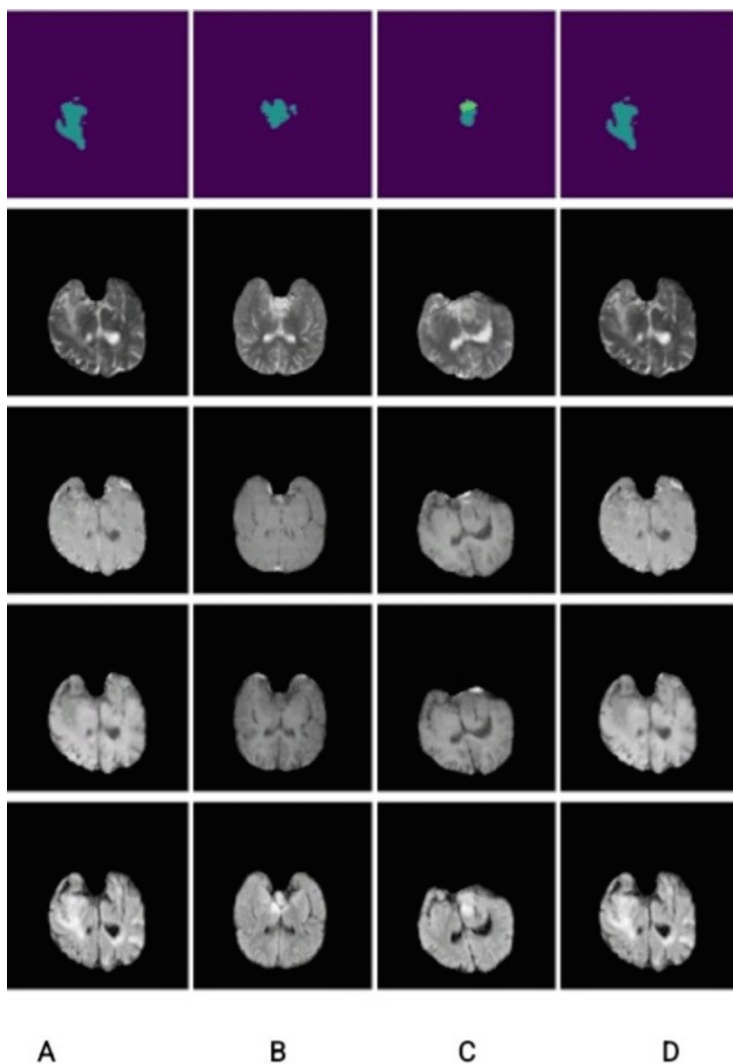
Excluded SSA training Cases A) 00051, B) 00097, C) 00041, & D) 00084 only for the optimized UNet baseline experiment [Predicted masks (top row), T2 (second row), T1ce (third row), T1 (fourth row), and T2-FLAIR (bottom row)]. This was not employed for the rest of the experiments. The predicted masks are shown with color coding as follows: background: purple, necrotic tumor core (NCR): blue, enhancing tumor (ET): yellow, peritumoral edematous tissue (ED): turquoise. (color figure online)
